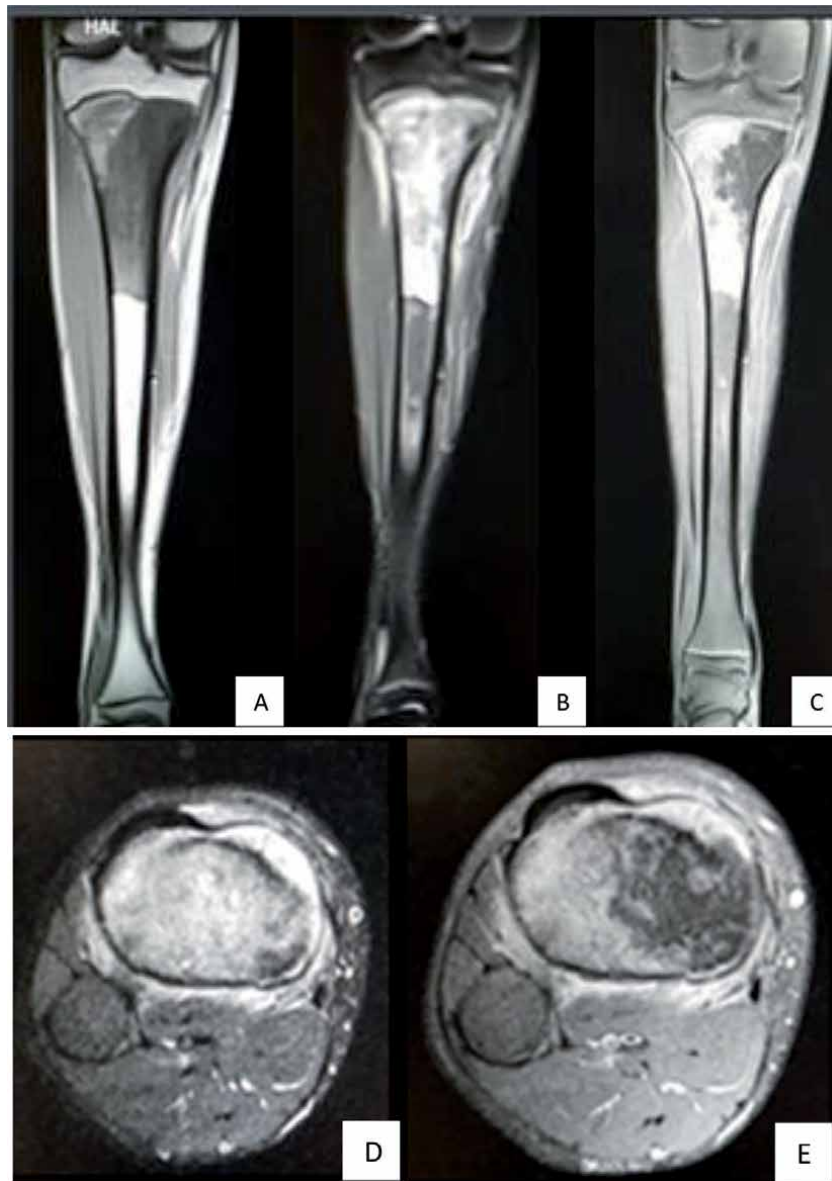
MRI of the tibia of a 15-year-old patient with an osteoblastic osteosarcoma of the proximal tibia respecting the physis (D, E). T1-weighted sequence (A), stir sequence (B) and T1-fat suppressed post contrast sequence (C).
